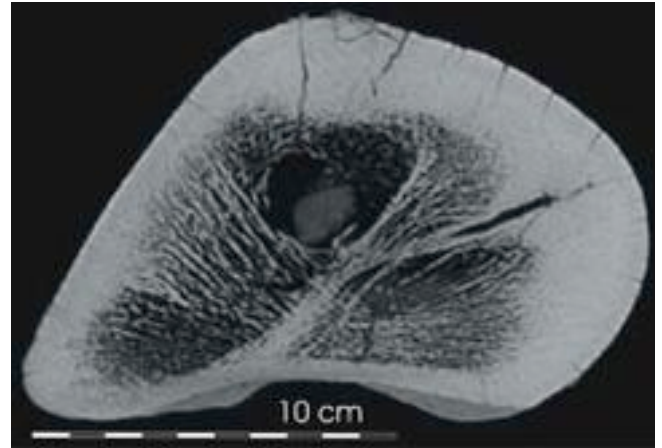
Radiography of a *Mammuthus primigenius* humerus (mid shaft position) from Krems-Hundssteig (Hu 76/1; Fladerer & Salcher-Jedrasiak 2008), Lower Austria. Please note the marrow cavity without spongy tissue.
